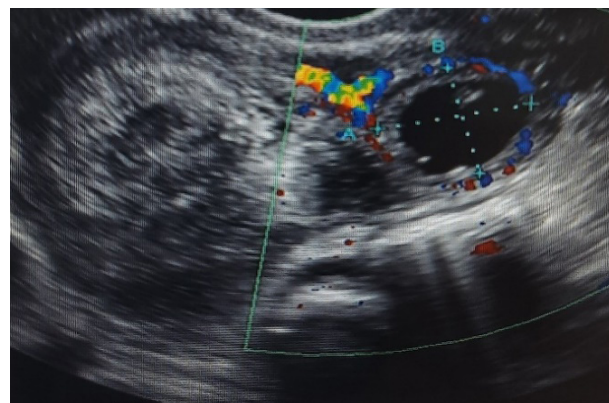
Ultrasound image demonstrating a mass in left adnexa measuring 4.0 × 3.5 cm and no intrauterine pregnancy.
